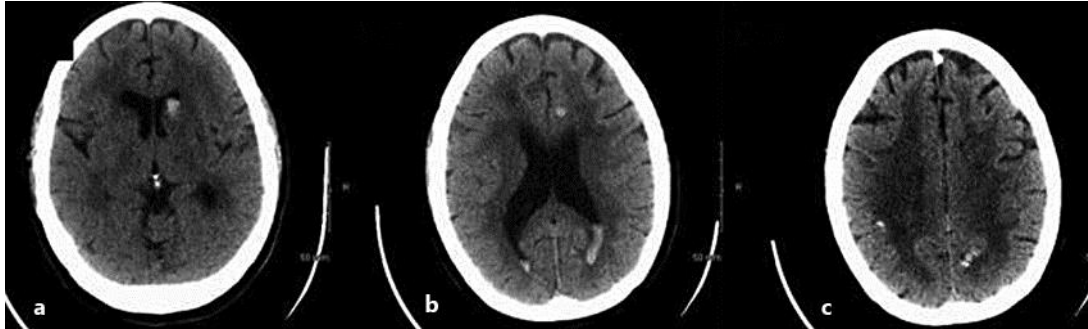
Noncontrast head CT after the patient decompensated. Hospital day 3 head CT images (a–c). There are extensive hemorrhagic foci along with intraventricular hemorrhages (increased since baseline head CT). Extensive patchy and confluent low attenuation in the periventricular as well as the deep white matter is again identified.
